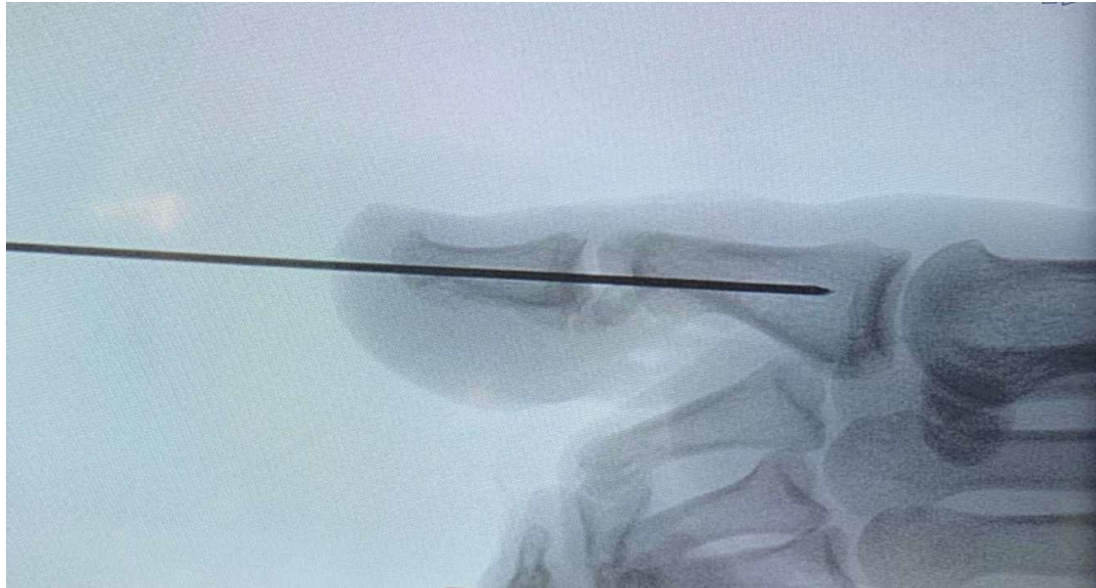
Intraoperative X-ray of the left great toe shows the K wire in proper position maintaining the alignment and reduction.
